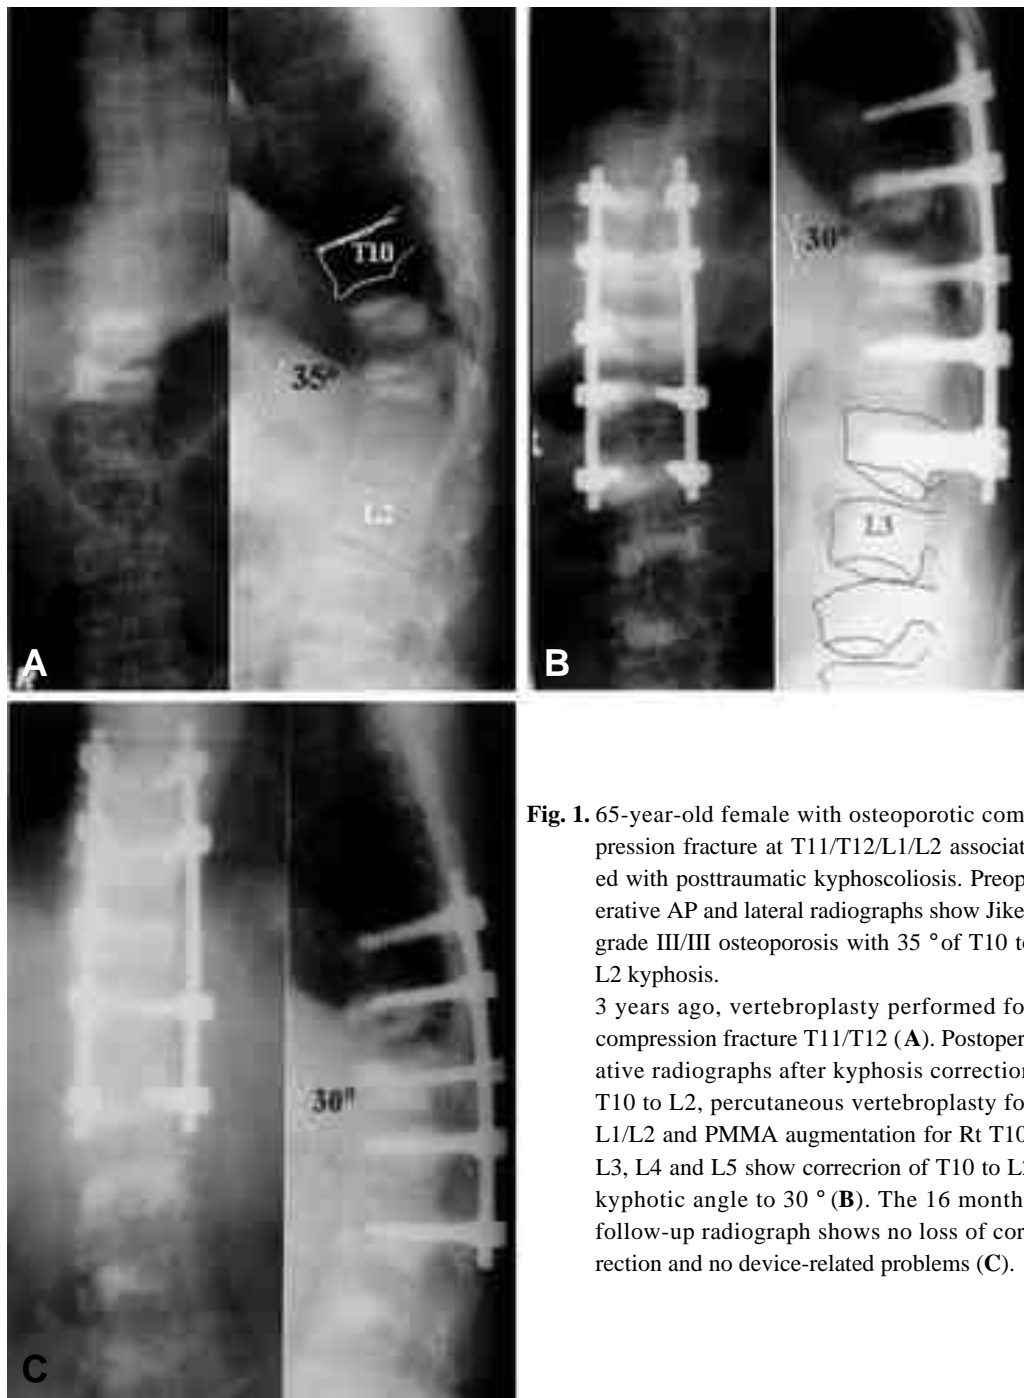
65-year-old female with osteoporotic compression fracture at T11/T12/L1/L2 associated with posttraumatic kyphoscoliosis. Preoperative AP and lateral radiographs show Jikei grade III/III osteoporosis with 35 ° of T10 to L2 kyphosis.
